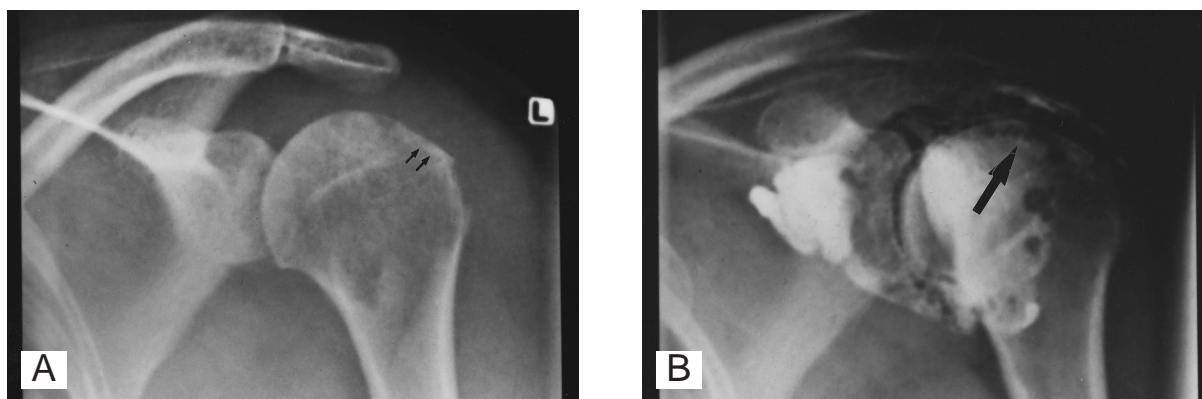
Radiograph of shoulder joint shows irregularity and sclerotic bone change in the great tuberosity of humerus (arrows). B: Shoulder arthrograph shows leakage of contrast medium to the subdeltoid bursa, which indicated rotator cuff tear (arrow).
